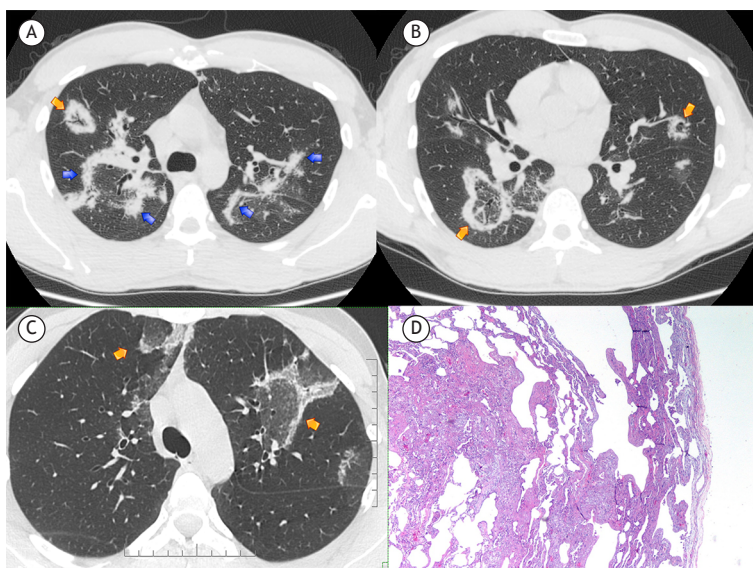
In A (case 1), axial HRCT scan of the chest at the level of the upper lobes showing the reversed halo sign (RHS) in the anterior segment of the right upper lobe (orange arrow), as well as bilateral peripheral and peribronchovascular consolidative opacities (band-like elements; blue arrows). In B (case 1), axial HRCT scan of the chest at the level of the lower lobes showing a well-defined lobulated RHS in the apical segment of the right lower lobe and a small RHS in the posterior segment of the left upper lobe (orange arrows). In C (case 2), axial HRCT scan of the chest at the level of the upper lobes showing the RHS in the anterior segment of the left upper lobe (orange arrow) and a slightly incomplete sign in the anterior segment of the right upper lobe (orange arrow). In D (case 2), note subpleural and septal fibrosis.
